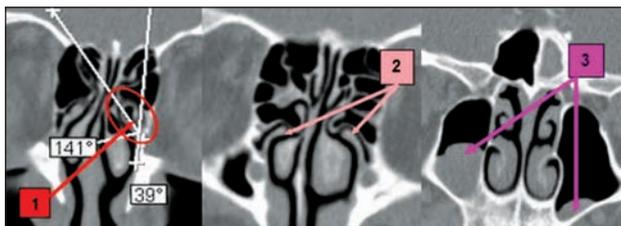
Paranasal sinuses CT scan, bone window, consecutive coronal slices: 1. uncinete process pneumatization, medialization (39° angle); 2. bilateral medialization of the uncinete process inserted on a giant ethmoid bulla; 3. bilateral maxillary sinus inflammatory process
